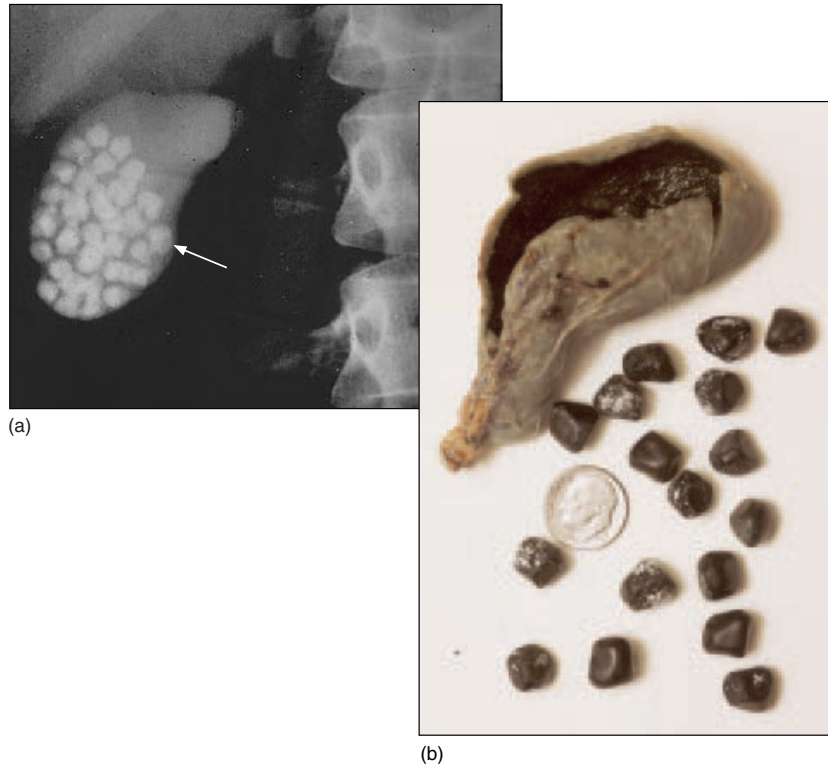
(a) A radiograph of a gallbladder that contains gallstones (biliary calculi). (b) Following surgical removal of the gallbladder (cholecystectomy), it has been cut open to reveal its gallstones. (Note their size relative to that of a dime.)
